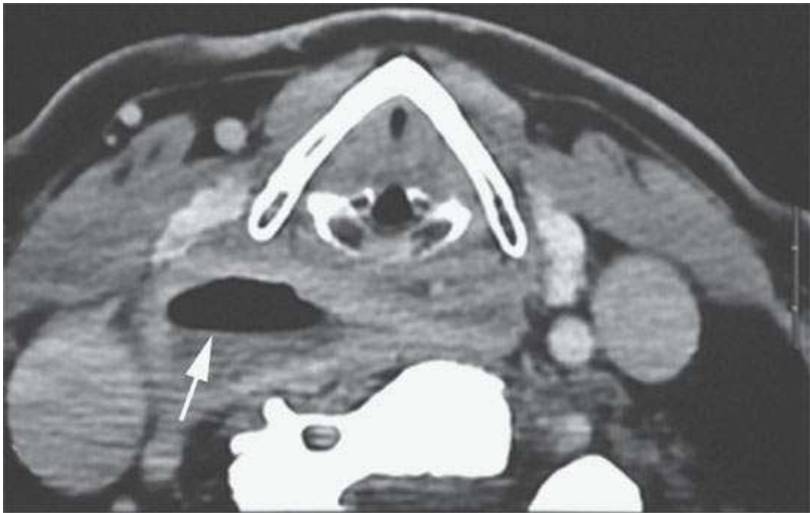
Contrast-enhanced computed tomography image shows an air–fluid level in the retropharyngeal space and deep neck (*arrow*) due to connection with the gastrointestinal tract and identifying it as a Zenker diverticulum.
